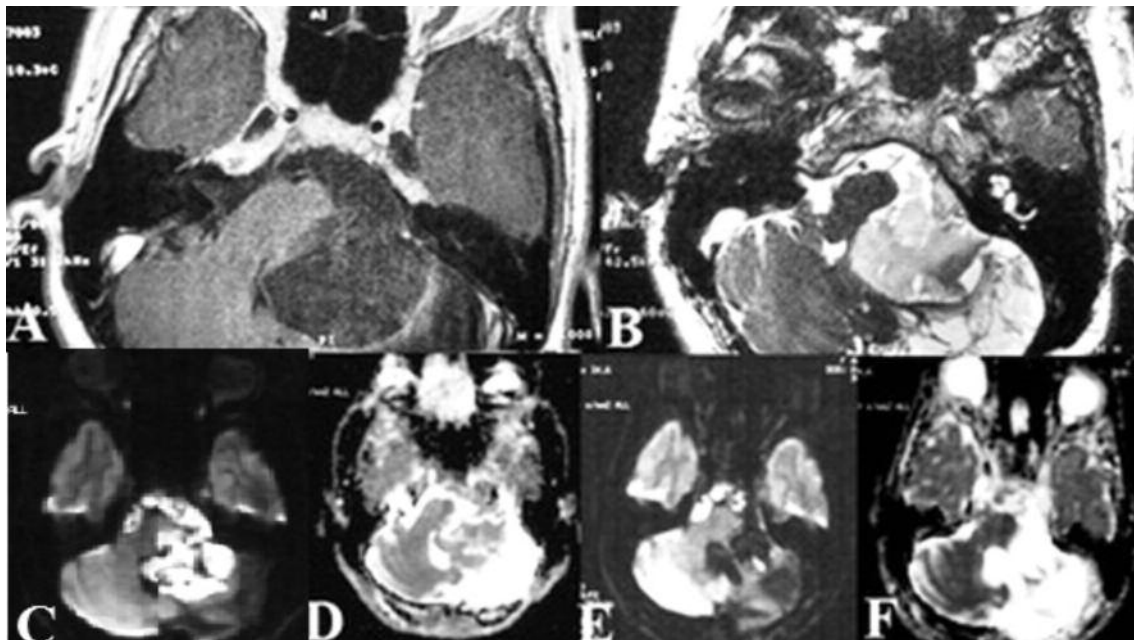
Huge epidermoid tumor extending to left anterior CPA region. A: Axial T1 WI shows a hypointense lesion; B: Axial T2 WI shows a hyperintense lesion; C: Preoperative DWI demonstrates diffusion restriction; D: Preoperative ADC map shows an isointense lesion. E, F: Residual epidermoid tumor is seen in the prepontine region on postoperative DWI and ADC map, respectively.
